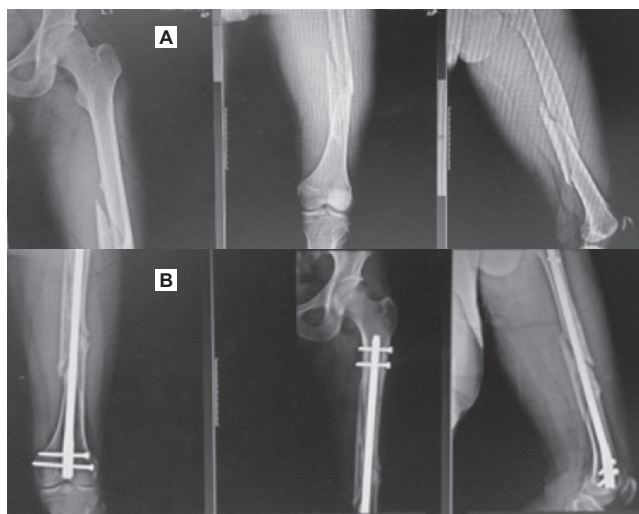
(a). Xray showing Fracture of left shaft of femur with distal 3rd extension b. 6mo postop x-ray of same Fracture managed with RG nail with the good healing progress.
